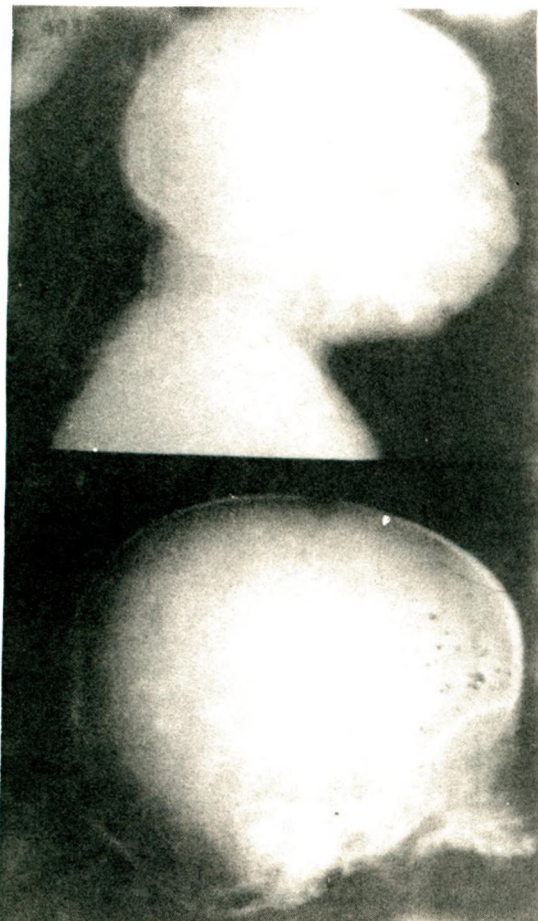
(a) Preoperative lateral skull roentgenogram of the 1st case.
